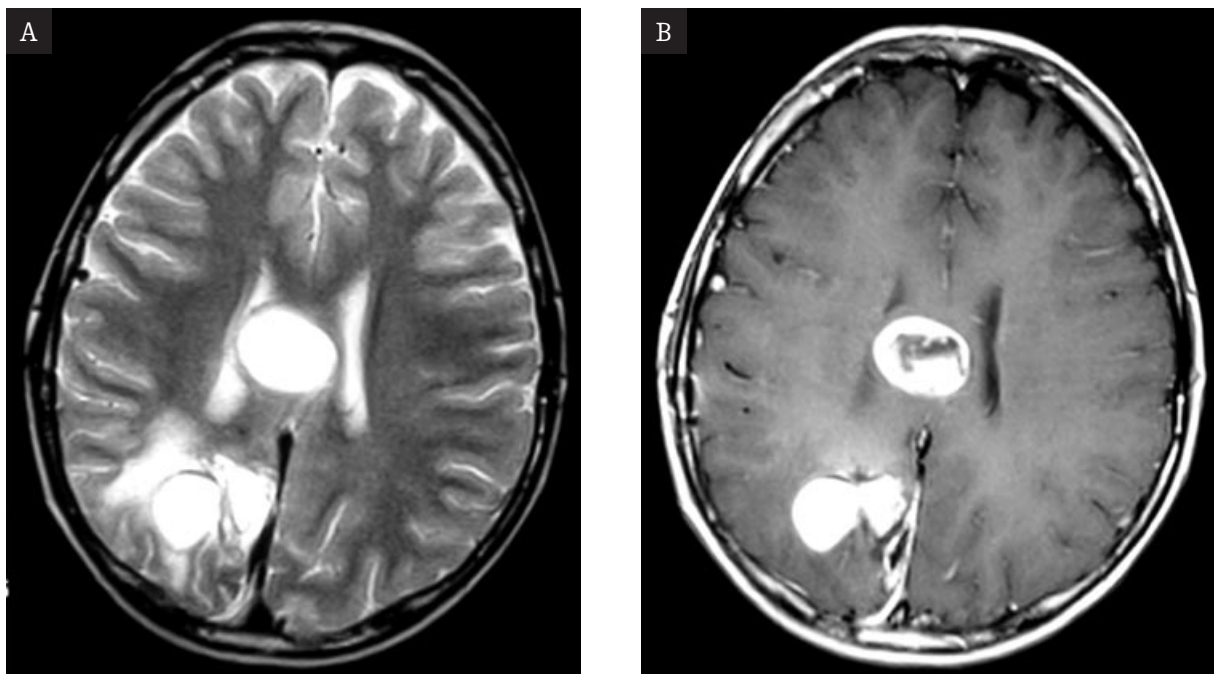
Metastases into the brain after the resection of pineoblastoma. Axial T2-weighted (A) and T1-weighted post-gadolinium (B) images. Metastatic mass in the corpus callosum and the second focus in the right occipital lobe. Edema of the deep white matter surrounding the brain tumor.
